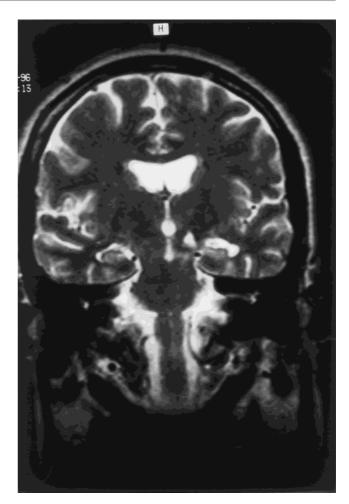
T2-weighted coronal MRI (Patient 5). Left subthalamic hyperintense lesion
